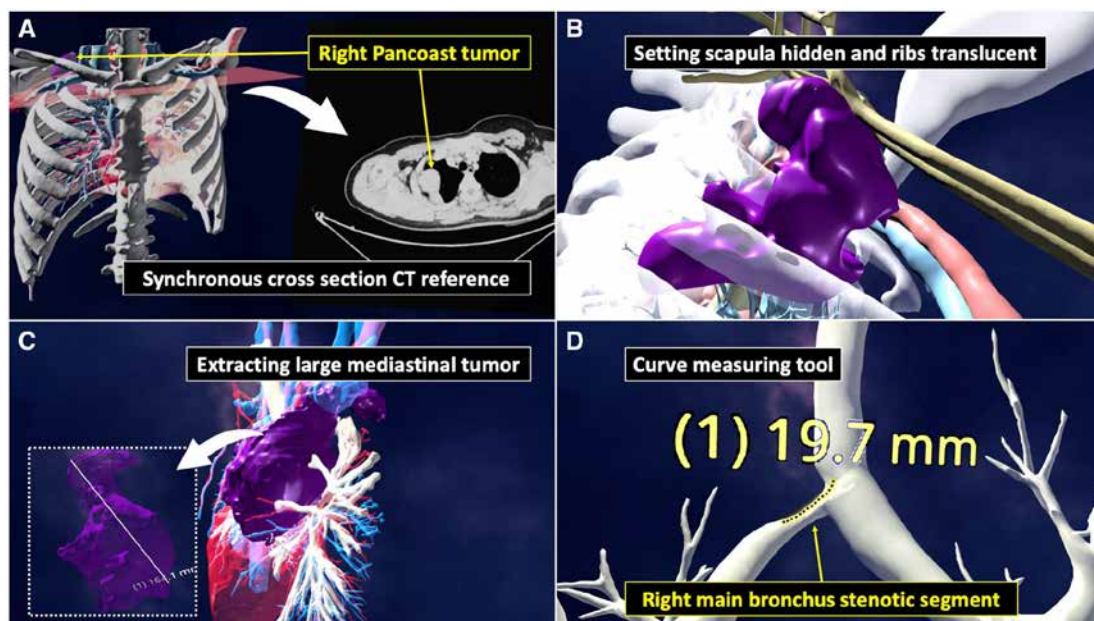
Features and functionalities within OpVerse that can be leveraged to address testing tasks. (A) A digital twin chest model of a 37-year-old female (case #1) with a right Pancoast tumour, displayed alongside the corresponding CT cross-section for reference. (B) Task 1: count the number of ribs affected by the tumour for case #1. (C) Task 2: measure the longest diameter of the anterior mediastinal pleomorphic lipoblastic sarcoma for a 28-year-old male (case #3). (D) Task 3: measure the curved length of the tuberculosis-related stenotic bronchus segment for a 38-year-old female (case #10). CT: computed tomography.
